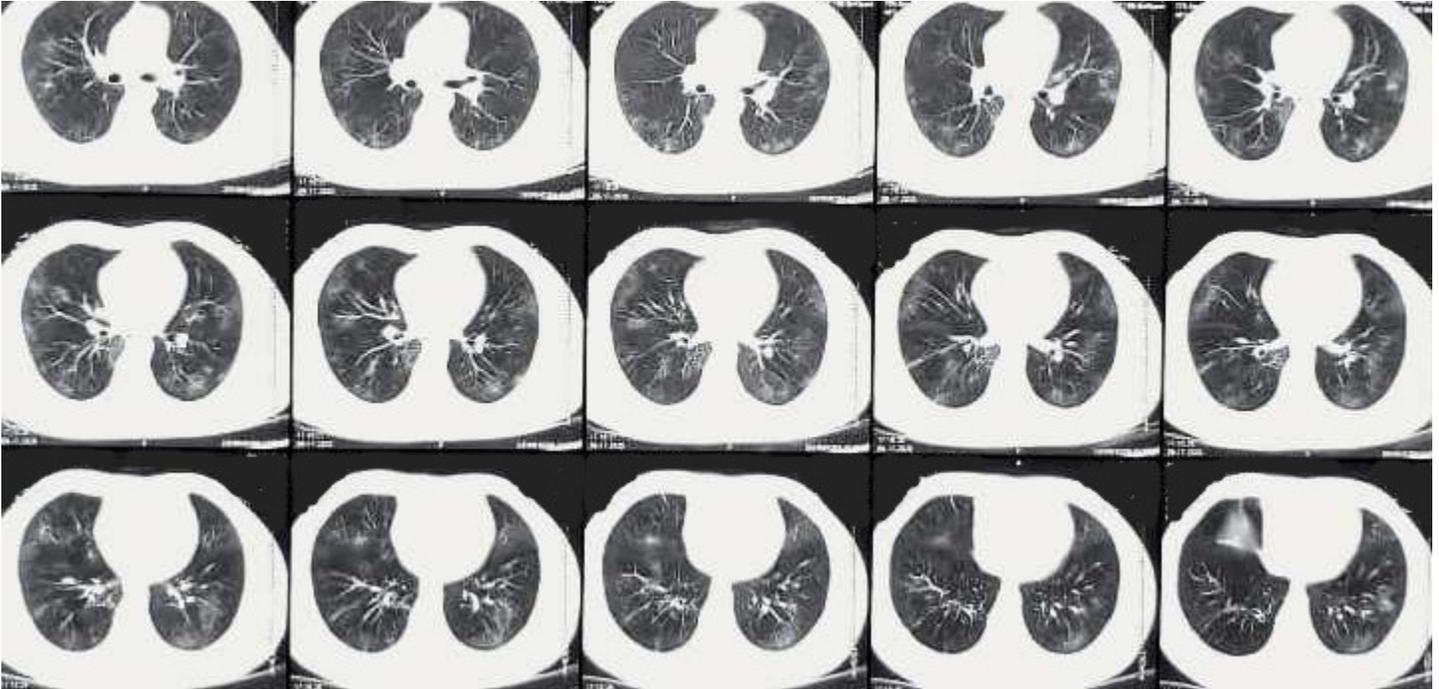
Chest CT scan of case 6 shows patchy peripheral opacities in both lungs in favor of COVID-19 diagnosis
